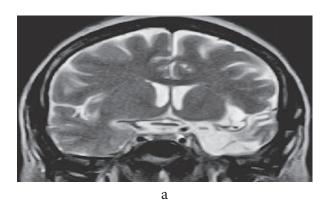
Brain MRI: extensive gliotic lesions in the region of the left temporal lobe (a) and atrophy of the brain parenchyma (b).
